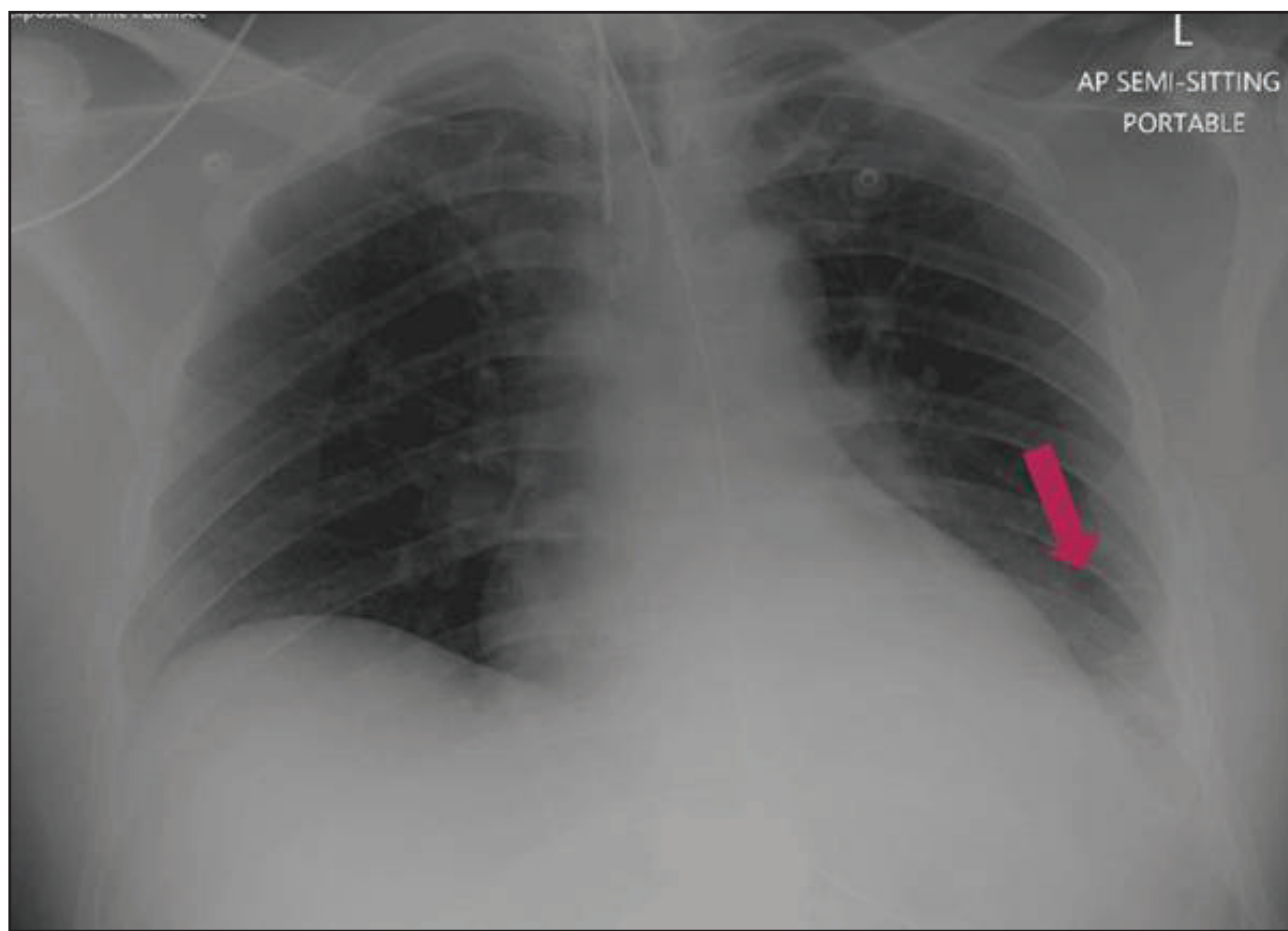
Portable chest radiograph demonstrating a new left basal infiltrate, supporting aspiration or early hospital-acquired pneumonia in the context of severe bulbar dysfunction and impaired airway protection.
